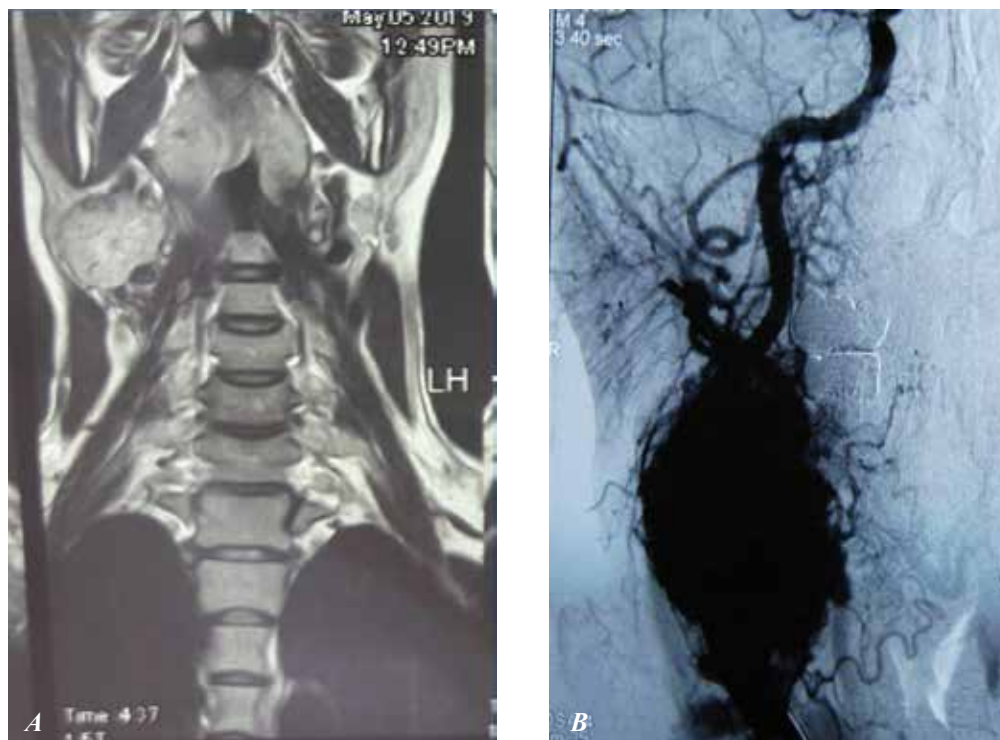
A - Computed tomography: formation of the right neck with dimensions 5.0x4.0 cm; B - arteriography: there is a hypervascular formation in the area of bifurcation of the right common carotid artery.
